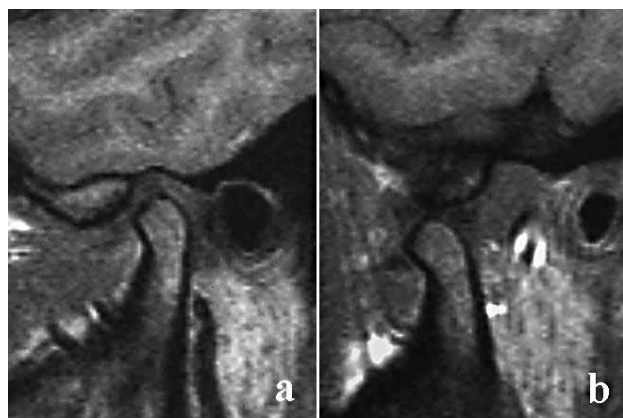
MRI showing TMJ of a 21-years old asymptomatic female person with disc in physiological position (a, closed mouth; B, open mouth).
